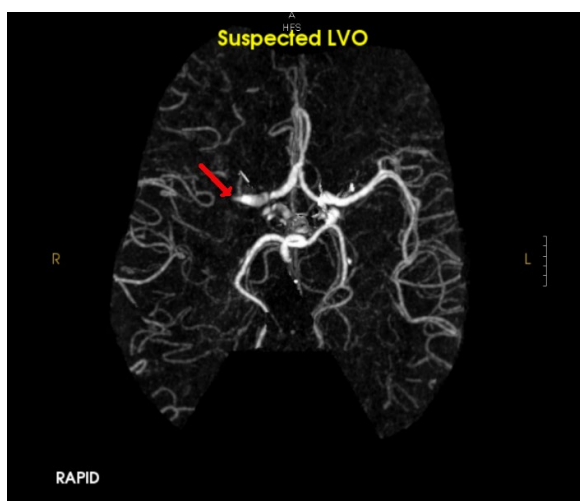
CT angiogram demonstrating large vessel occlusion (LVO) in right middle cerebral artery (arrow). Further review of study would also demonstrate occlusion of the right internal carotid artery (not shown).
